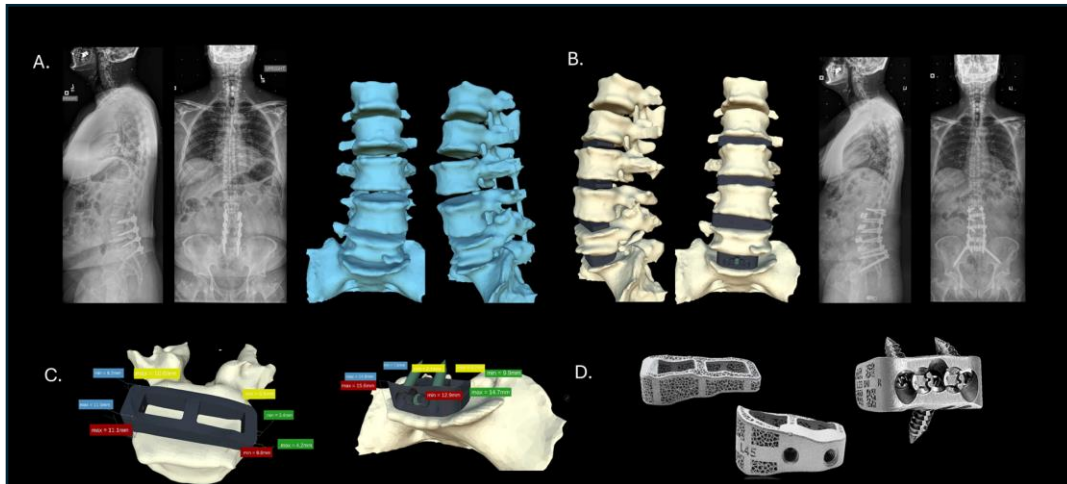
Case example. The patient is a 65-year-old male with persistent symptoms, adjacent segment disease, and global sagittal malalignment following a previous postero-lateral lumbar fusion. (A) AP and lateral views of preoperative X-Ray and 3D reconstruction models (blue). (B) AP and Lateral views of the 3D reconstruction plan (beige) and post-operative X-Ray. (C) Example of personalized implant geometry for lateral and anterior approaches, with colored tags specifying implant dimensions. Device geometry was derived from mapping the intervertebral space of the corrected alignment with superior and inferior implant surfaces matching vertebral endplate topography. (D) Images of sample implants for lateral and anterior approaches.
